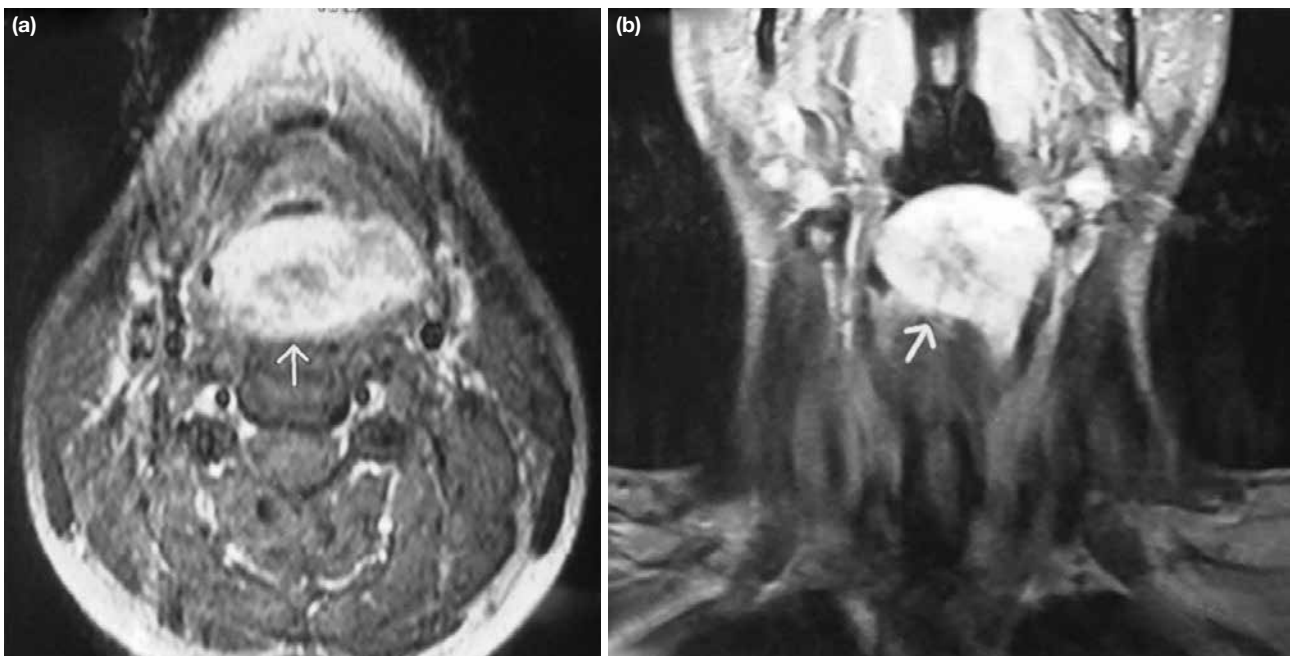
a, b. Coronal (a) and axial (b) MR images. Red arrow indicates the mass.
